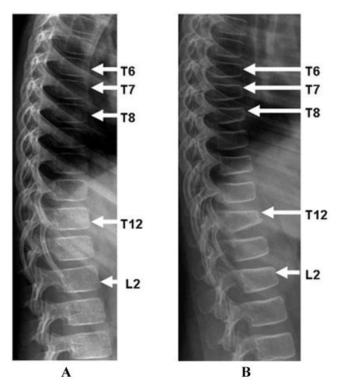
Spine radiographs from a 7-year-old girl with mixed connective tissue disease. At study entry (A), her spine radiograph showed no signs of vertebral fractures; however, she manifested multiple painful vertebral fractures during the observation period (B). This patient was excluded from the bone health natural history analyses because she required bisphosphonate therapy to treat the symptomatic fractures; however, a brief description of her skeletal phenotype is provided in the Results.
